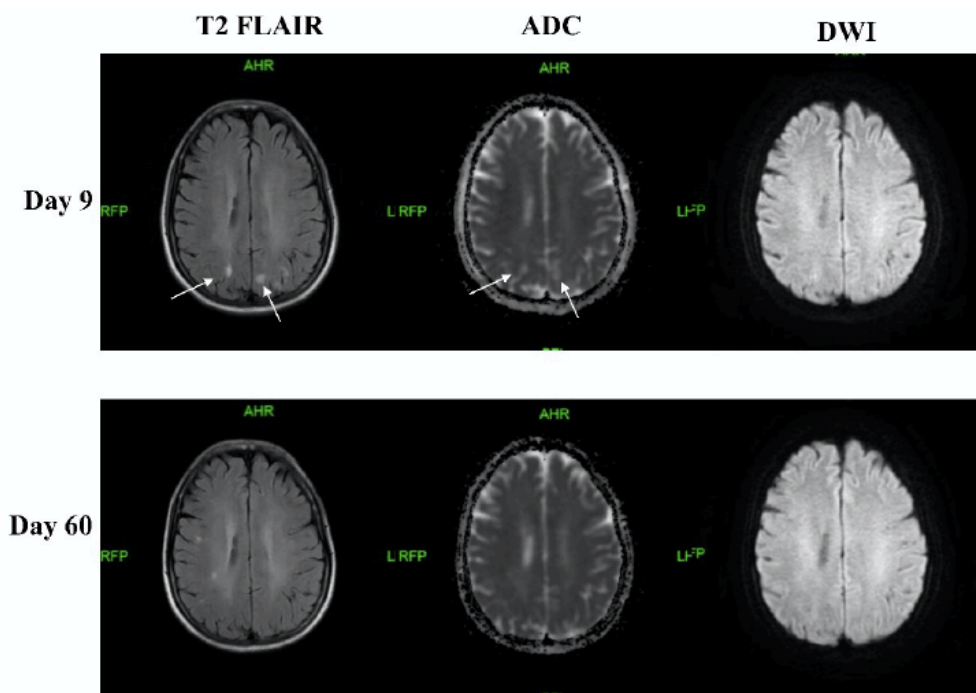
Serial changes in brain magnetic resonance imaging findings. Representative magnetic resonance images of T2 FLAIR, ADC measured by DWI, and DWI were obtained on the 9th and 60th hospital days. The white arrows mark the lesion in the bilateral frontoparietal occipital white matter.
